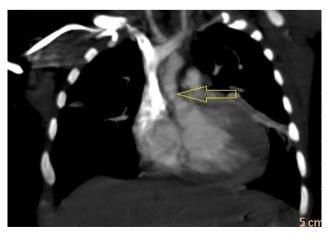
Cardiac CT (Coronal section) showing SVAS.
